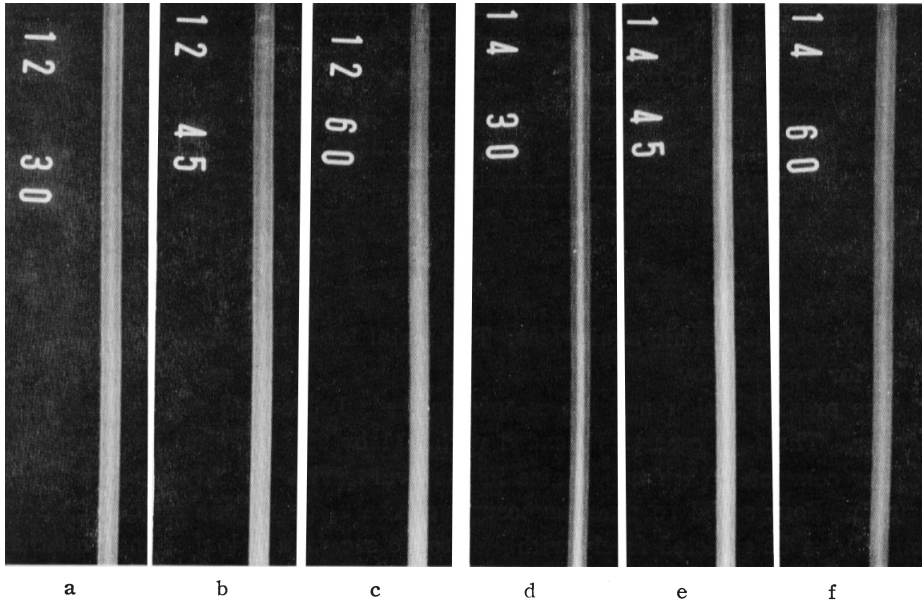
Experimental radiographs
